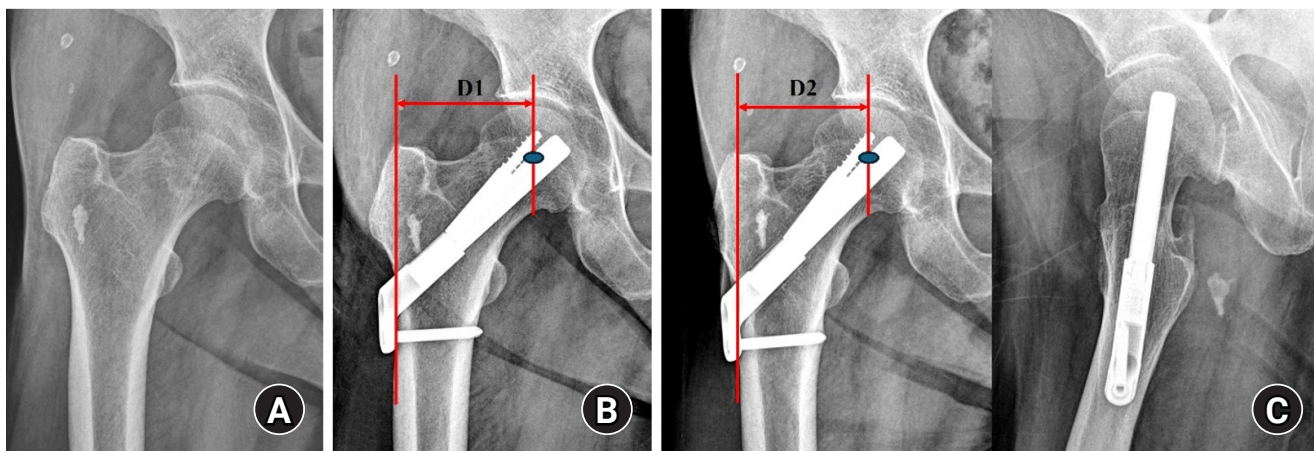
(A, B) A 67-year-old female patient with a right femoral neck fracture (Garden type 1) treated with the femoral neck system. (C) The postoperative 4-year radiograph shows a well-healed fracture site and no complications related to the implant. Femoral neck shortening (D2–D1) was calculated as the difference in the distance from the center of the femoral head to the lateral cortex of the femur between the immediate postoperative and final follow-up radiographs.
